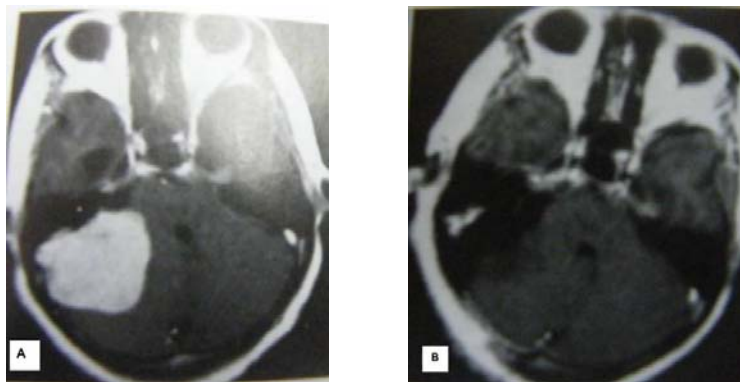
(A) T1-enhanced MR image demonstrating a tumour lateral to the IAC. (B) Follow up T1 enhanced MR image revealing total resection of the tumour.
